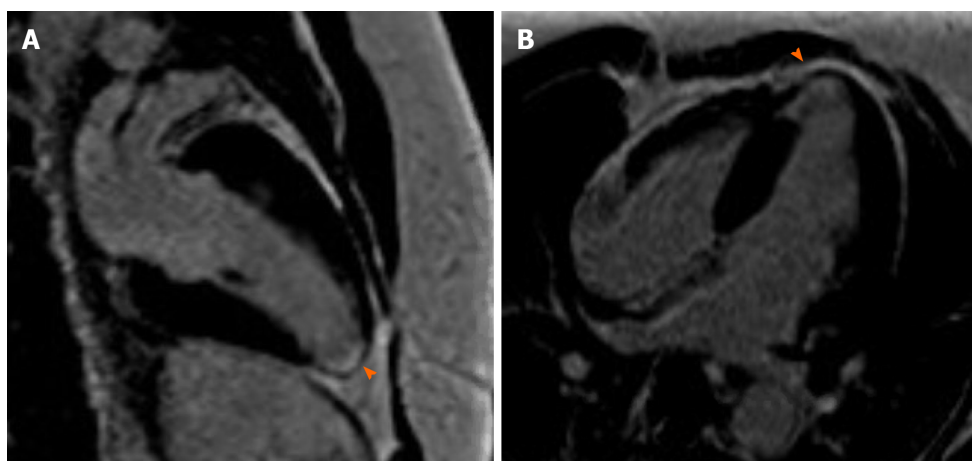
Cardiac magnetic resonance imaging shows delayed gadolinium enhancement suggestive of apical scarring and nonviability.
